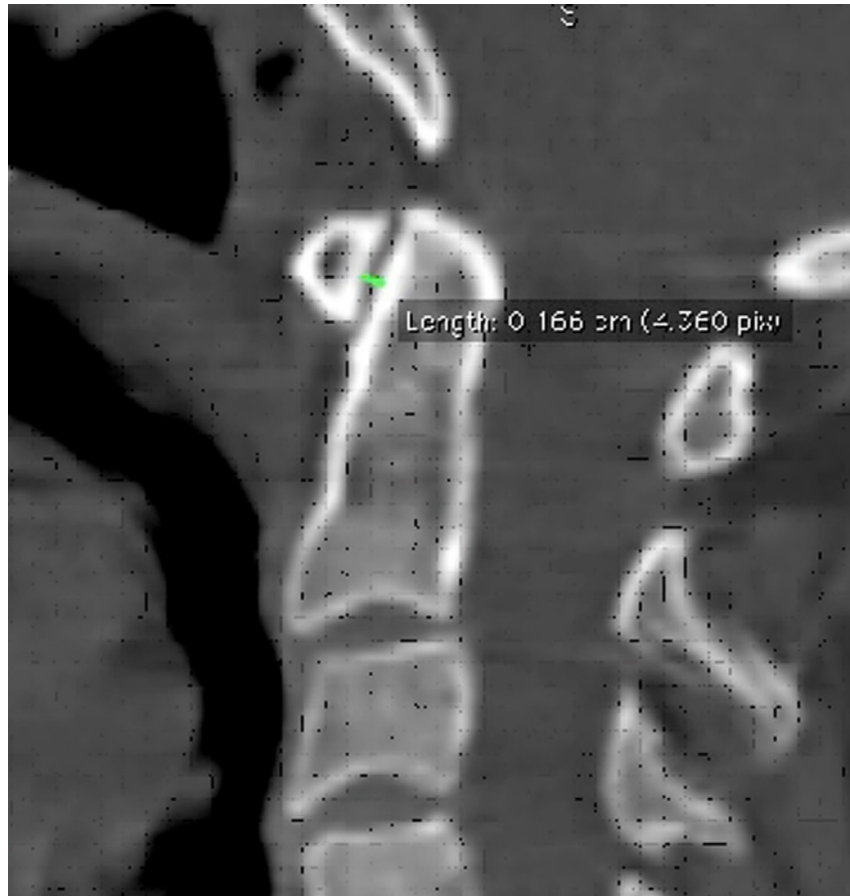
Measurement of the atlantodental distance in cervical CT sagittal images
